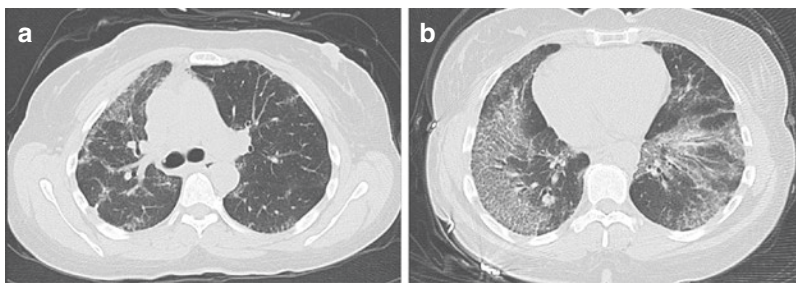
Chest CT imaging from a patient presenting with acute-onset dyspnea. The CT shows a diffuse pattern of ground glass opacities affecting both lungs and present centrally as well as peripherally. In the context of an acute-onset dyspnea, infection must be considered.
